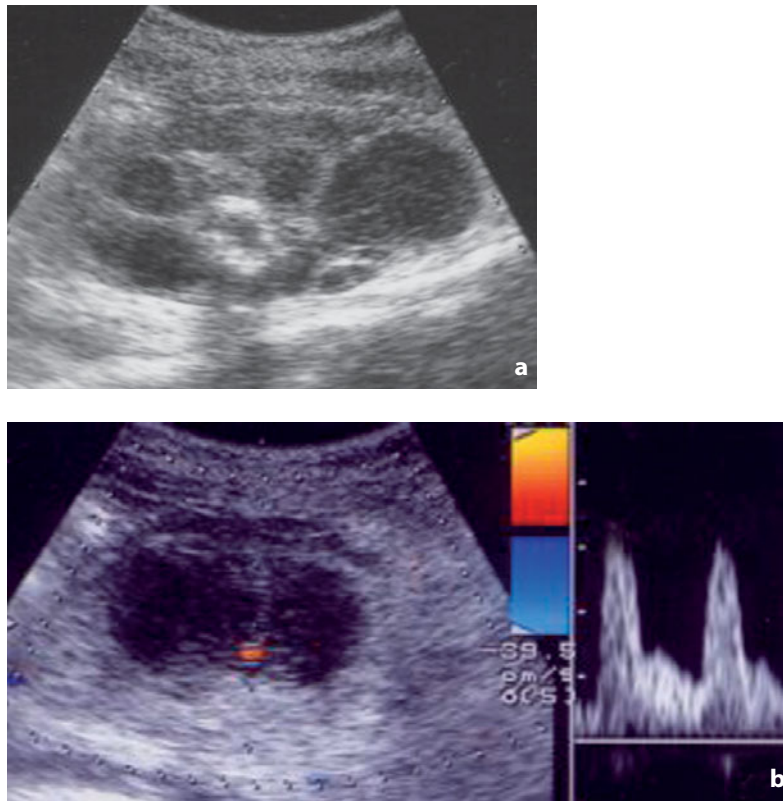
Transabdominal ultrasonography. Mucinous adenocarcinoma. a Large and multilocular left adnexal mass with cystic components separated by thin septations and highly vascular solid components at color Doppler (b)
